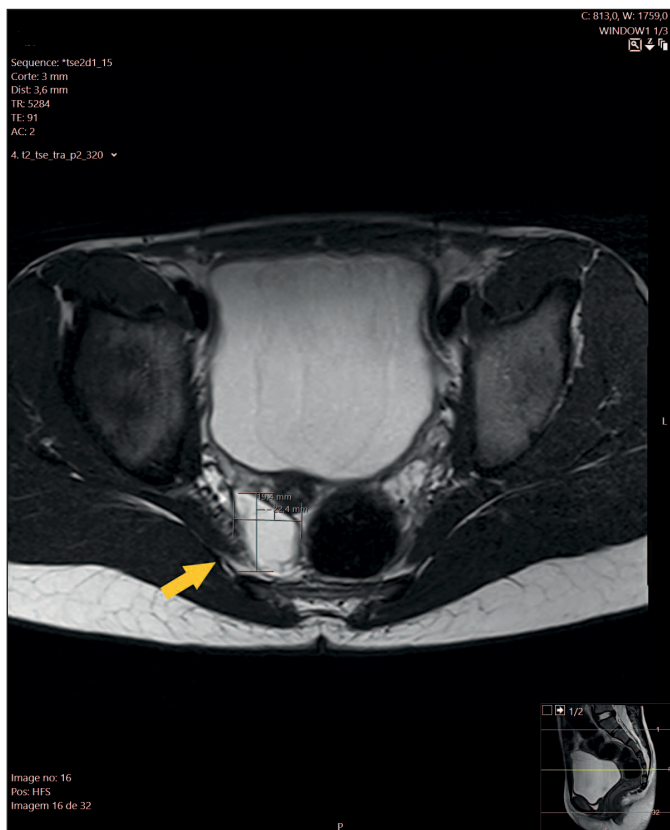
Pelvic MRI showing cystic lesion in the right ovary
